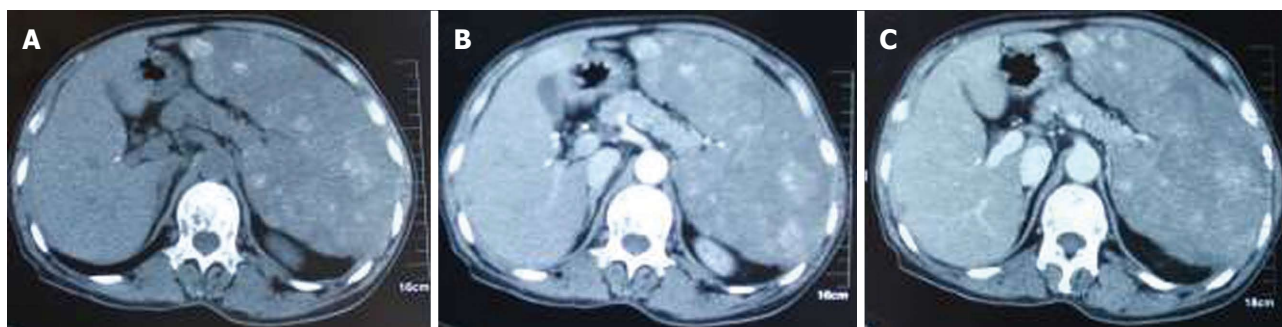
Computed tomography imaging. A: Computed tomography plain scanning showing multiple hyperintense lesions in the spleen; B: During the arterial phase, the lesions showed heterogeneous enhancement; C: In the portal phase, the lesions were more hyperdense than the splenic parenchyma.
